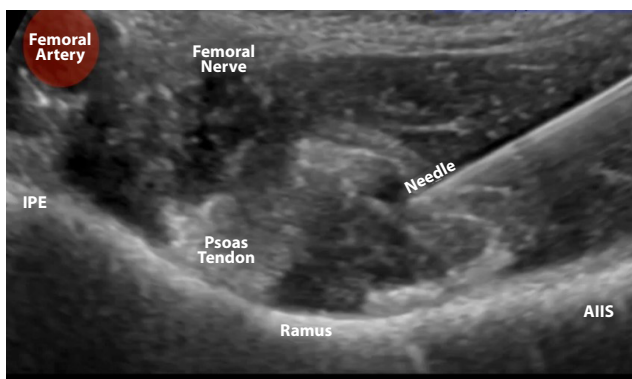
Ultrasound image demonstrating needle approach. Note how the needle is seen in-plane, approaching the psoas tendon. The femoral artery and femoral nerves are clearly seen and avoided.
